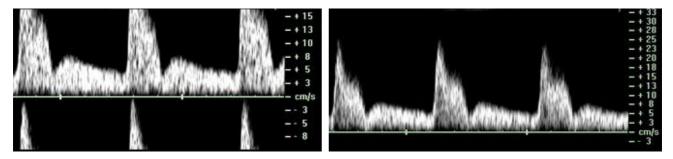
Example of aliasing and correction of the aliasing. Left: waveforms with aliasing, with abrupt termination of the peak systolic and display this peaks bellow the baseline. Right: Sonogram clear without aliasing. Correction: increase the pulse repetition frequency and adjust baseline (move down)
